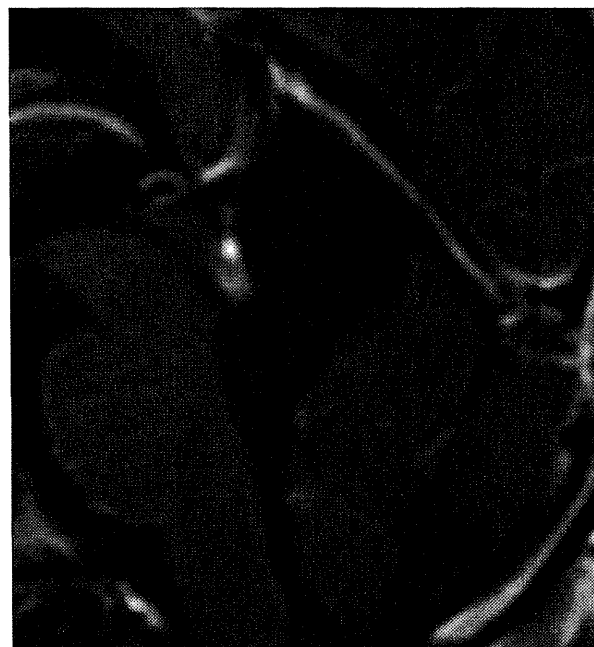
Postoperative sagittal Gd-enhanced T1-weighted MR image revealing a residual tumor at the dorsal midbrain and resolution of compression of the brainstem.
